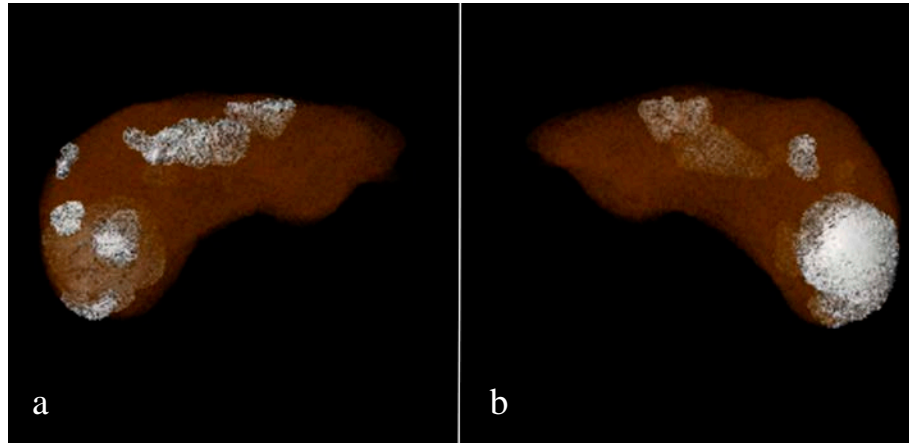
Preoperative computed tomogram. Multiple bilobar lesions of all liver segments. A. Reconstruction of the frontal section of the liver, anterior view. B. Reconstruction of the frontal section of the liver, posterior view
